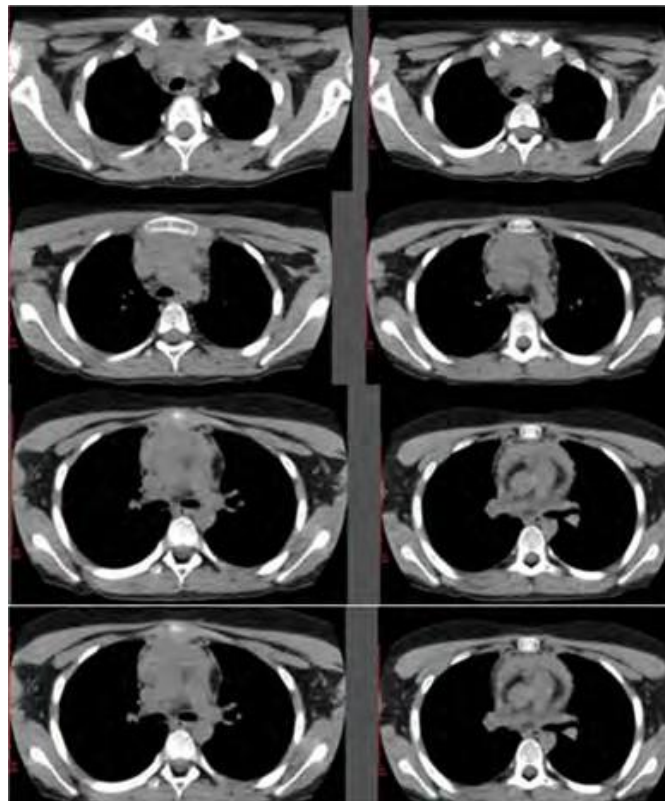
CT of thorax from March 2022.
